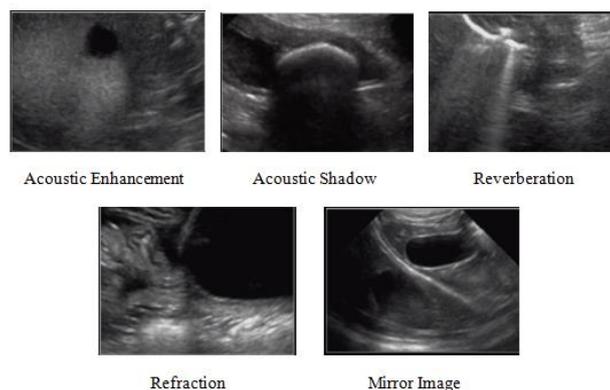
Common Artefacts in Ultrasound Imaging [25]
